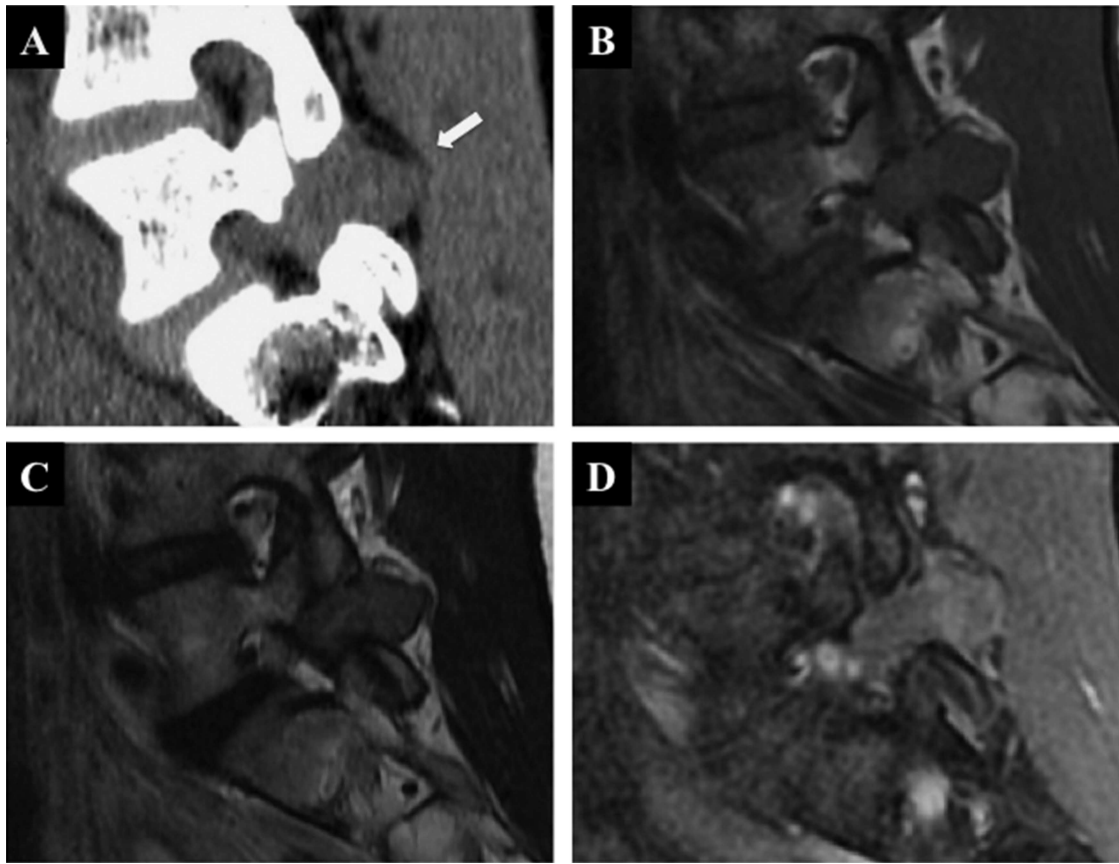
The mass located on the left pars defect at L5. Sagittal computed tomographic scan (A), T1-weighted image (WI; sagittal view) (B), T2-WI (sagittal view) (C), and gadolinium-enhanced, fat saturated T1-WI (sagittal view) (D). The arrows shows tumor mass.
